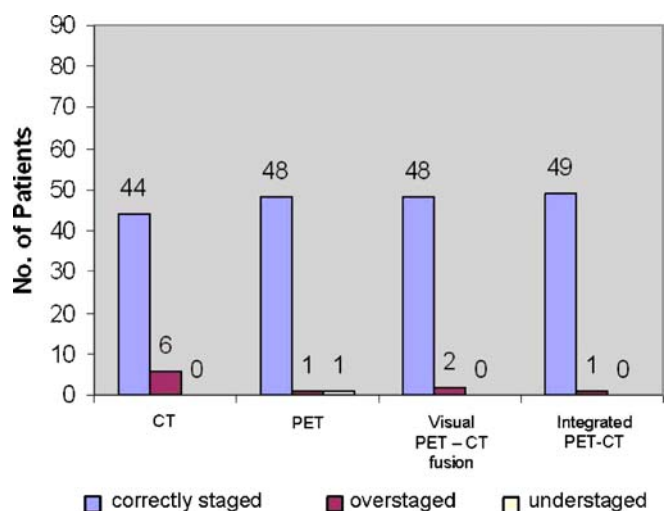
Accuracy of metastatic (M) status for integrated PET-CT compared with CT, PET and visually correlated PET-CT
